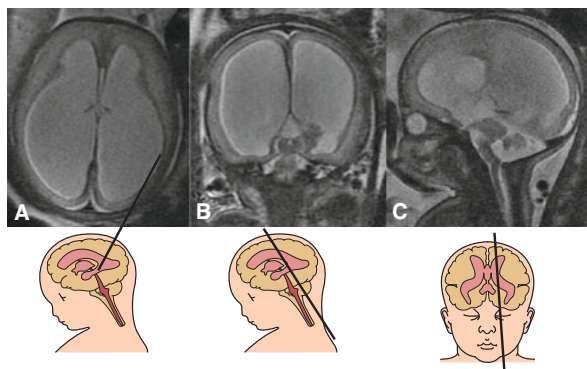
MRI at 34 postmenstrual weeks of a fetus with WWS. Axial (A) and coronal (B) sections show severe ventriculomegaly with thin lissencephalic cortex and dysplastic cerebellum. (C) Sagittal plane shows the characteristic Z shape of the brainstem and vermian dysgenesis. (Courtesy of Dr. Chen Hoffmann, Tel-Hashomer, Israel.)
